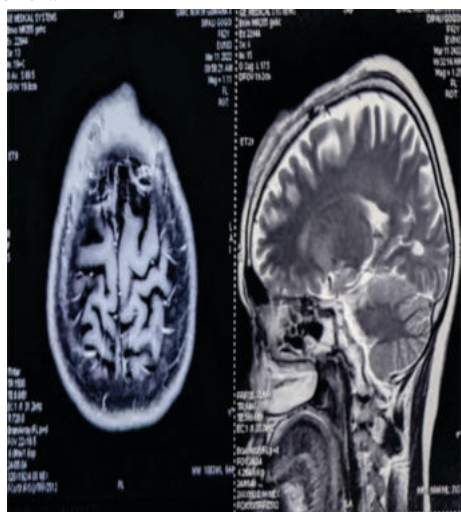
Preoperative T1 Weighted MRI Sequences In Axial & Sagittal Sections Showing The Lesion
